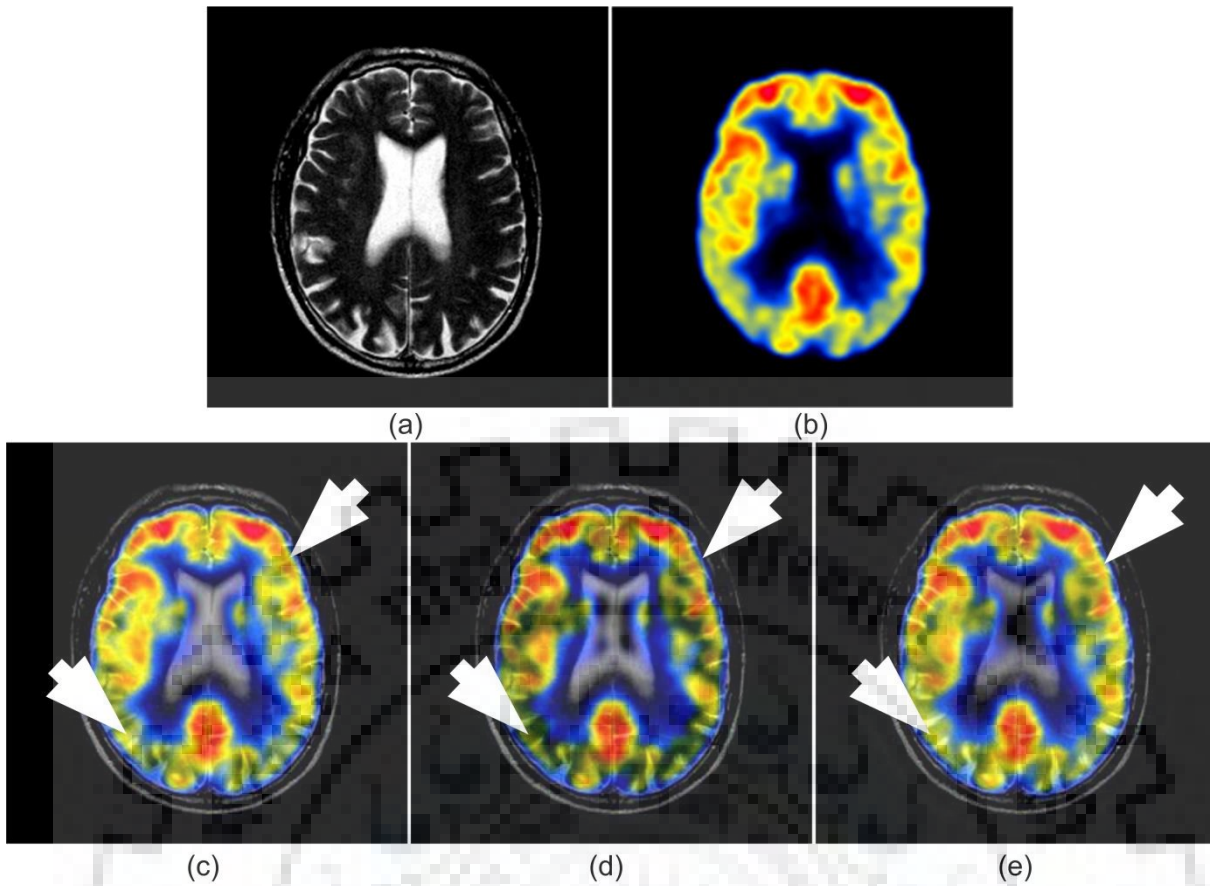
Comparative analysis of (a) MR image (b) PET image and fusion results of (c) Ganasala and Kumar, 2016 [48] (d) Yang et al., 2017 [203] (e) Proposed H-MIF
